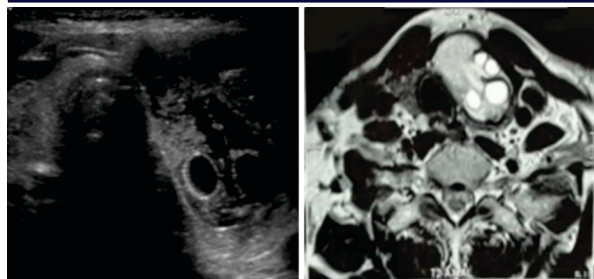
USG & T2W MRI- Shows a well defined cystic lesion with multiple daughter cysts in the left lobe of thyroid
